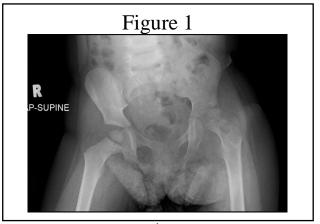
Xray prior 2<sup>nd</sup> washout
